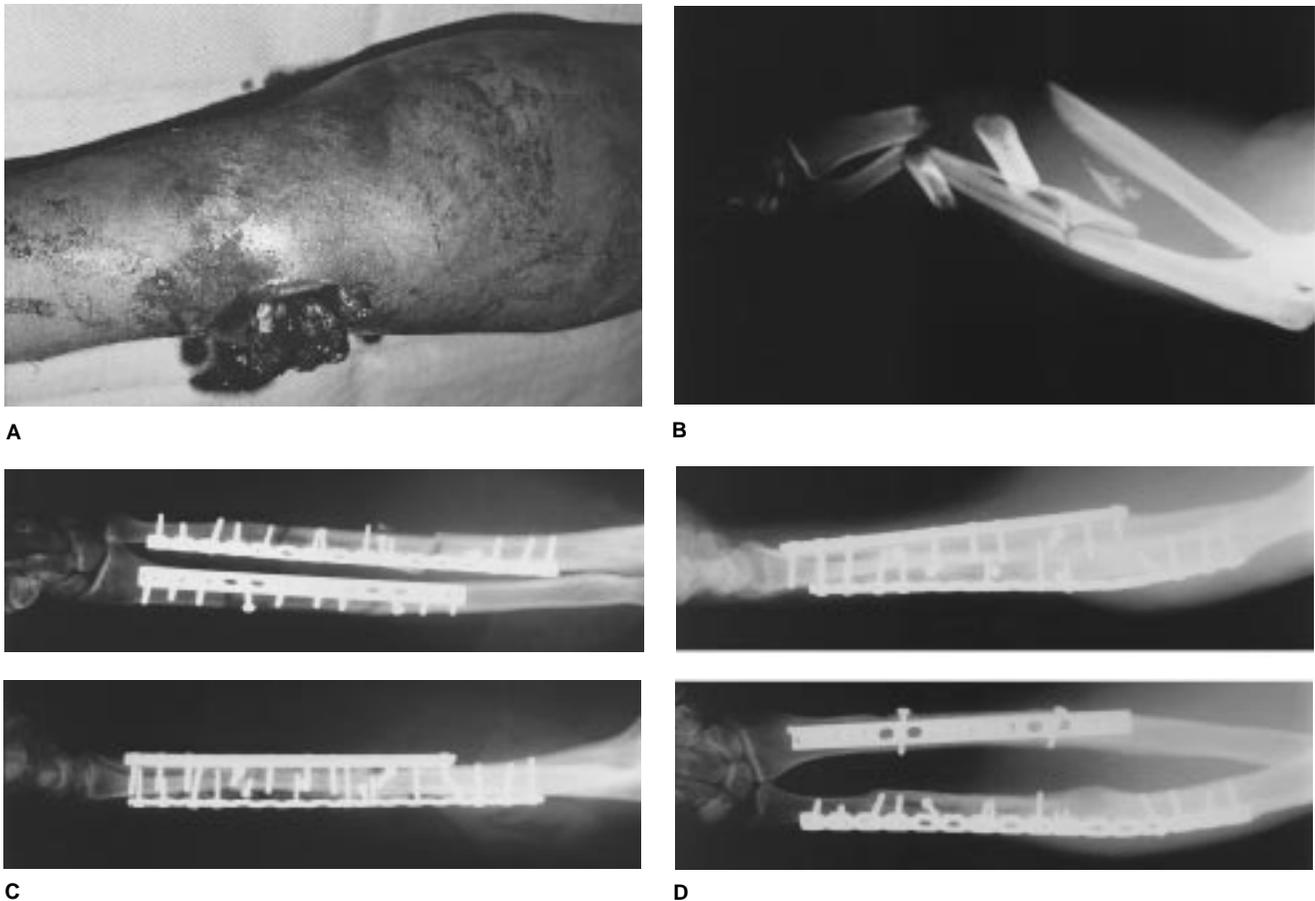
A, Severe crush injury of the forearm, resulting in a crush/burst injury of the forearm muscles and musculotendinous junctions. B, Radiograph depicts severe comminuted fractures of both forearm bones. The ulna shows segmental fracture with longitudinal strips in the fractured segment. C, After thorough debridement, both bones were rigidly fixed. Fasciotomy was performed with primary skin grafting. D, The fractures are fully healed. The ulna required one bone-grafting procedure.
